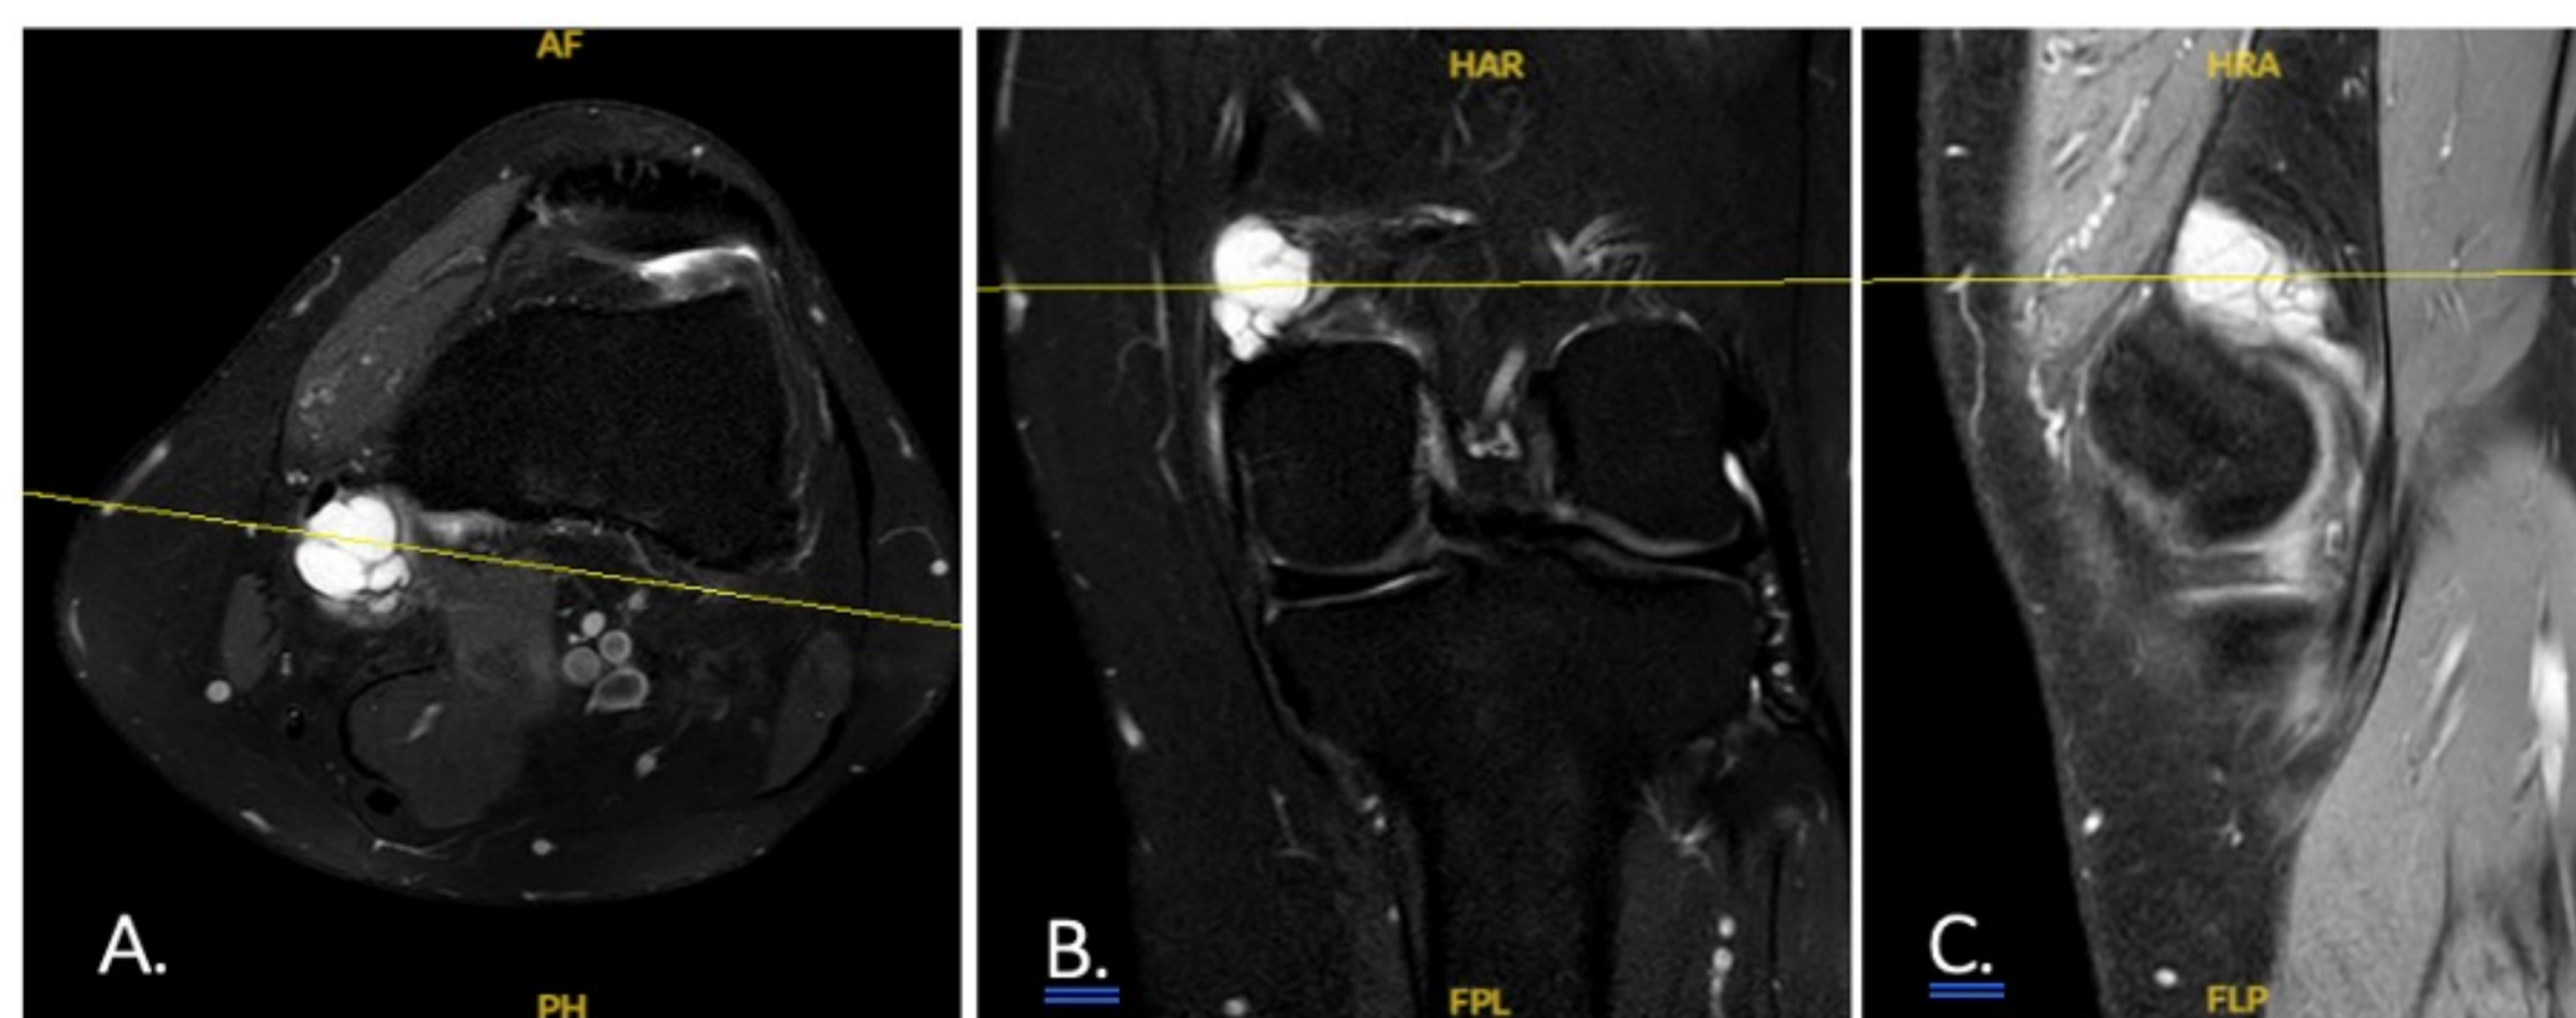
MRI of the left knee with a 2.3x2.0x1.4 cm ganglion cyst with multiple thin septations adjacent to the adductor magnus tibial insertion. A. Axial view of the knee demonstrating the ganglion cyst adjacent to the adductor magnus tibial insertion. B. Coronal view of the ganglion cyst. C. Sagittal view of the ganglion cyst.
